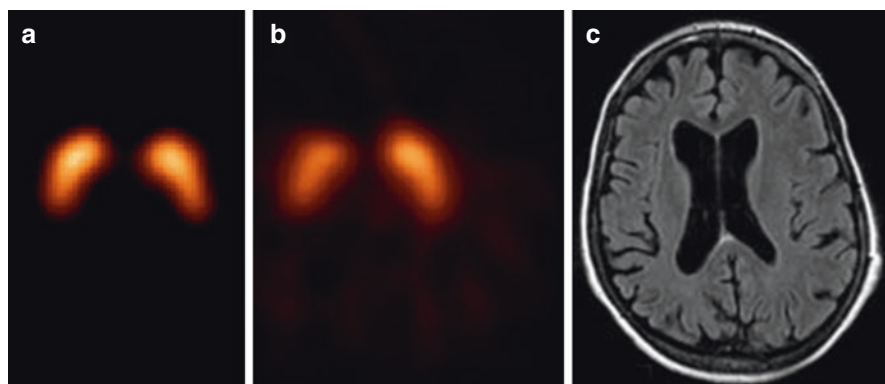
[¹²³I]β-CIT SPECT scan of a healthy control (A) and a patient suffering from corticobasal degeneration (B), as well as an MR image of the same patient (C). The corticobasal degeneration has led to an asymmetrical degeneration of the nigrostriatal pathway (B) and a unilateral atrophy of the brain (C), both contralateral to the body side that showed clinical motor signs (Reprinted from ‘Bewegingsstoornissen’; editors ECh Wolters and T van Laar, Amsterdam, 2002, The Netherlands)
